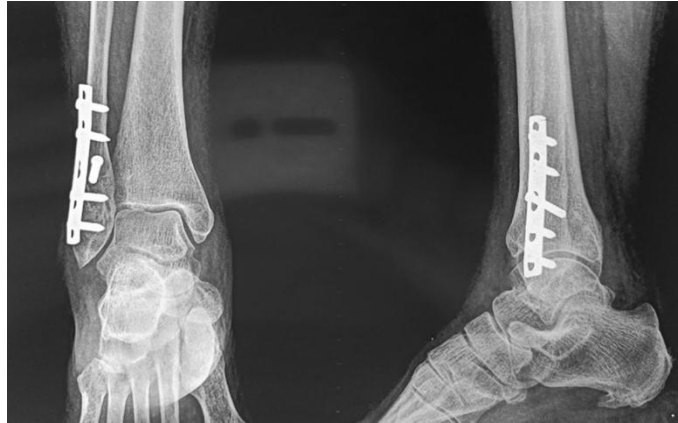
Post-operative xray showing internal fixation with neutralization plate using 1/3<sup>rd</sup> tubular plate and 3.5mm interfragmentary screw.
